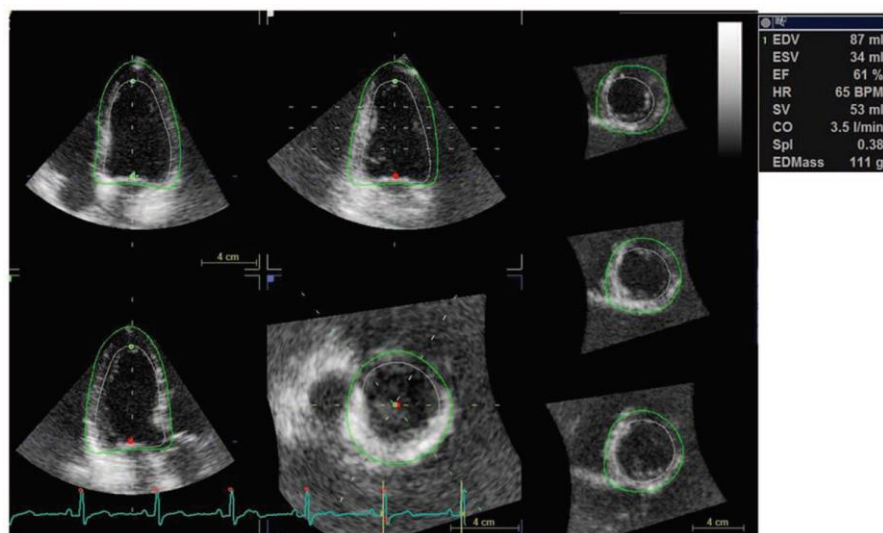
Model of three-dimensional echocardiographic assessment of left ventricular mass, volumes and stroke volume in a hypertensive patient of our study population with elevated left ventricular mass/end-diastolic volume ratio. CO, cardiac output; EDMass, left ventricular mass; EDV, left ventricular end-diastolic volume; EF, left ventricular ejection fraction; ESV, left ventricular end-systolic volume; HR, heart rate; LVM/EDV ratio, left ventricular mass/end-diastolic volume ratio; Spl, sphericity index; SV, stroke volume.
